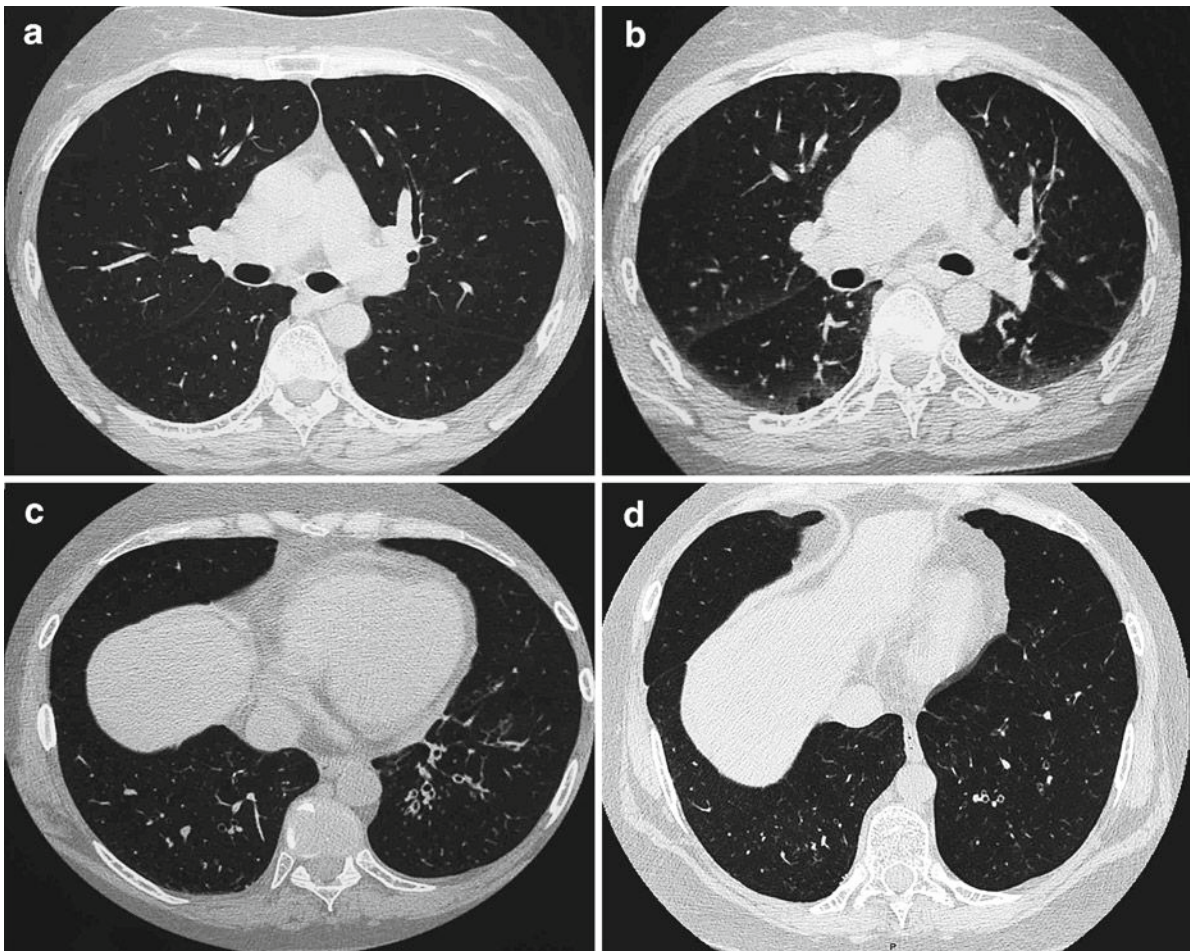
Evolution of lung high-resolution computed tomography (HRCT). In April 1999, HRCT revealed no parenchymal abnormalities or air trapping on inspiratory (a) and expiratory
